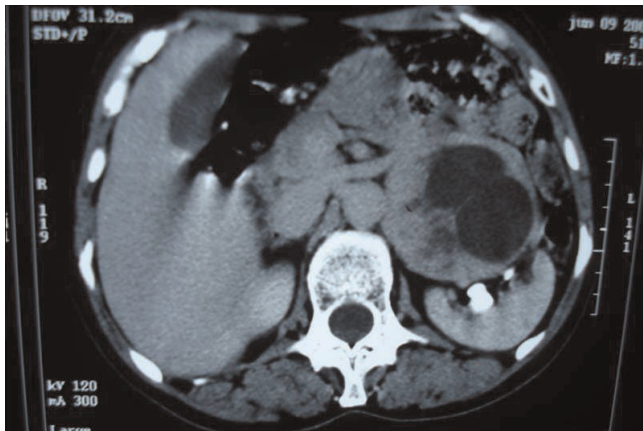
CT scan at level of left renal vein shows a heterogeneous soft-tissue mass.
